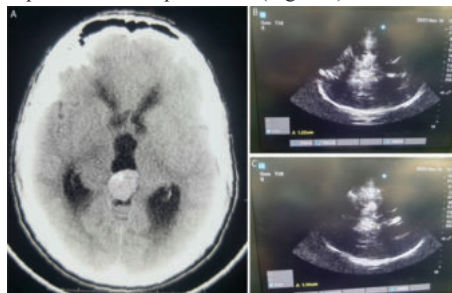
(A) Preoperative third ventricular width on CT image; Preoperative (B) and Postoperative (C) third ventricular width on ultrasonography.
